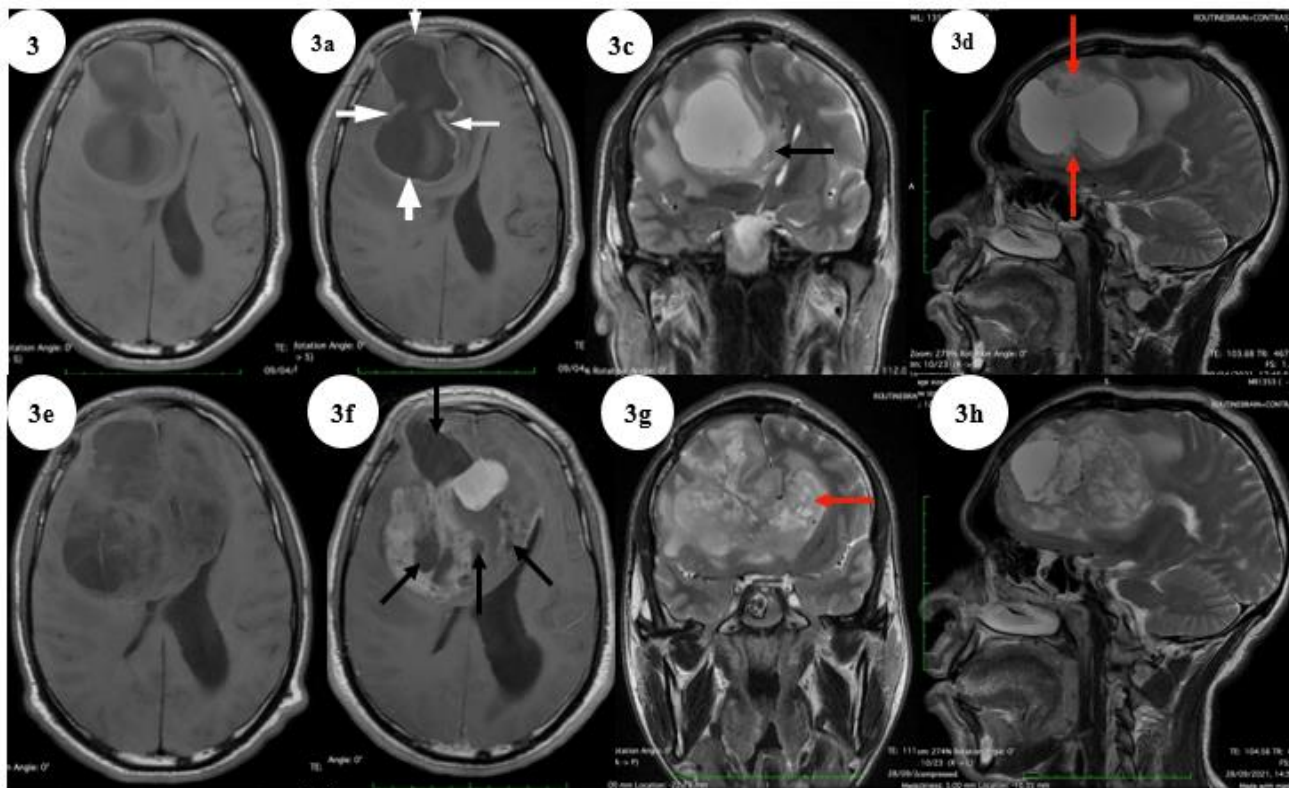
(a-d): Brain Magnetic Resonance Imaging (4 months post-surgery).
